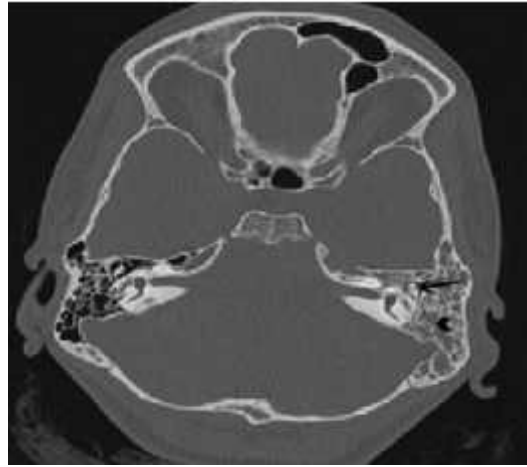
HRCT axial image shows soft tissue density noted within the left middle ear cavity (arrow) and mastoid cavity (arrow head) suggestive of otomastoiditis.
